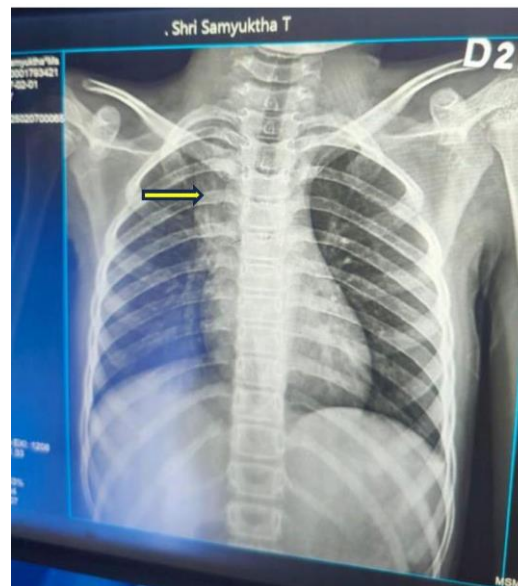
Chest X-ray of a 5-year-old child with normal lung fields and prominent thymic shadow.
